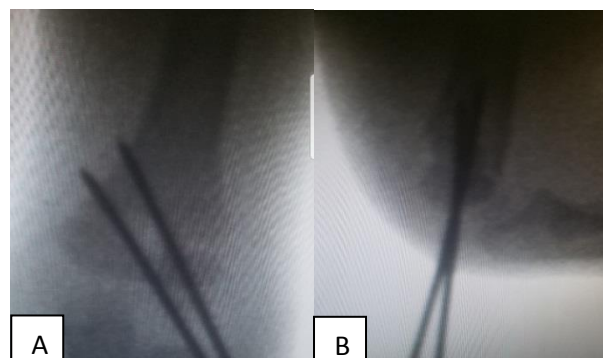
Radiograph of a Gartland type III fracture fixed with two lateral K wires. (A) Anteroposterior view, (B) lateral view.
